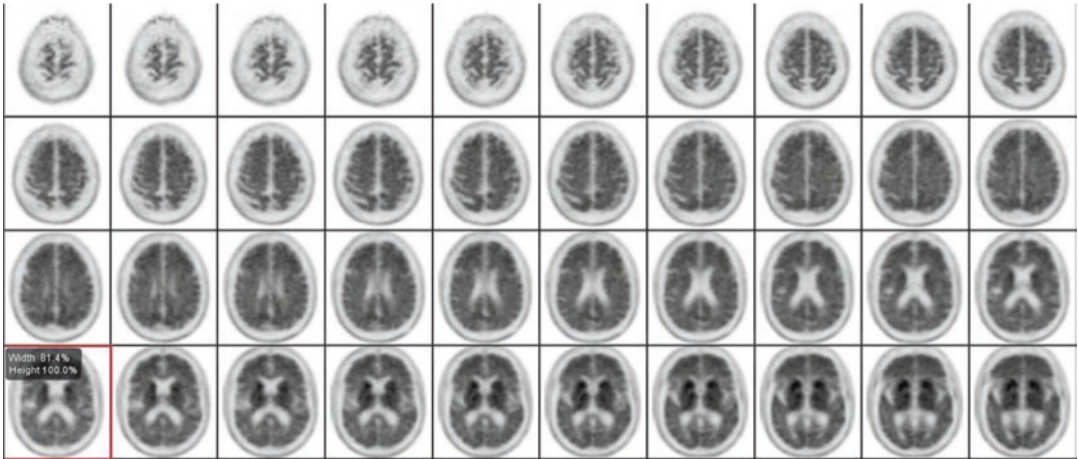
Positive AMYViD scan: AMYViD brain scan of a 55-year-old male with clinical suspicion of early onset of Alzheimer's disease. After the injection of 10 mCi of AMYViD radiotracer in a dimly lit and quiet room, PET images were obtained at 30 min on the GE VCT PET/CT scanner. Images were reconstructed and sectioned in the transverse, sagittal, and coronal planes for interpretation. Non-contrast CT scan was also performed for attenuation correction and to obtain an assessment of brain atrophy. On visual inspection of the transverse sections, beginning inferiorly at the cerebellar hemispheres to assess white and gray matter uptake and progressing
